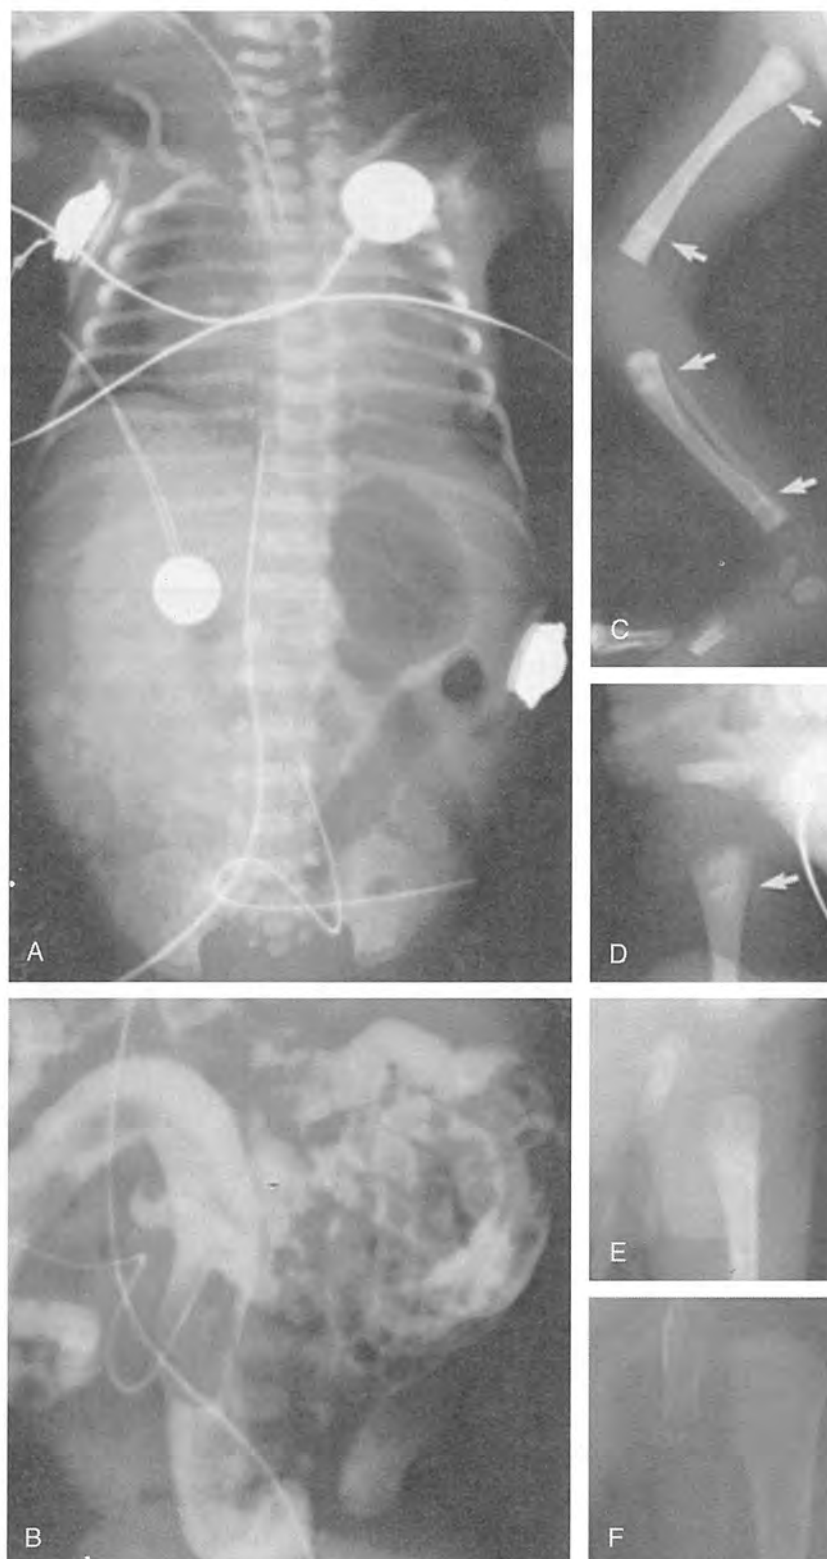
Congenital Lyme disease. An infant presented at birth with thrombocytopenia, cardiomyopathy, meconium ileus equivalent, and intrauterine growth retardation. *A*, Chest and abdominal radiograph at 1 day of age show cardiomegaly and mottled increased density in the right lower quadrant from inspissated meconium. *B*, Lower GI study at 1 day of age demonstrates impacted meconium in the distal ileum. Bone radiographs show (*C*) sclerotic transverse metaphyseal bands at birth (arrows), (*D*) fading metaphyseal bands after antibiotic therapy for 5 days (arrow), (*E*) further fading of the metaphyseal bands after antibiotic therapy for 16 days, and (*F*) resolution of the metaphyseal bands by 7 months (patient 24 in Table 11-8).
